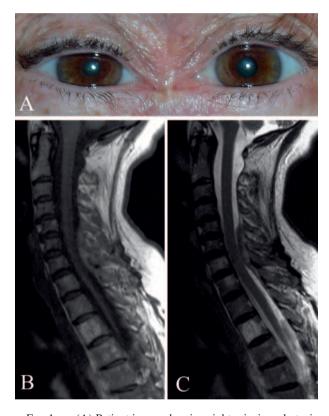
(A) Patient image showing right miosis and ptosis suggestive of HS. Sagittal T1(B) and T2 (C) weighted MRI revealing a hyperintense epidural hematoma extending from C6 to T1.
